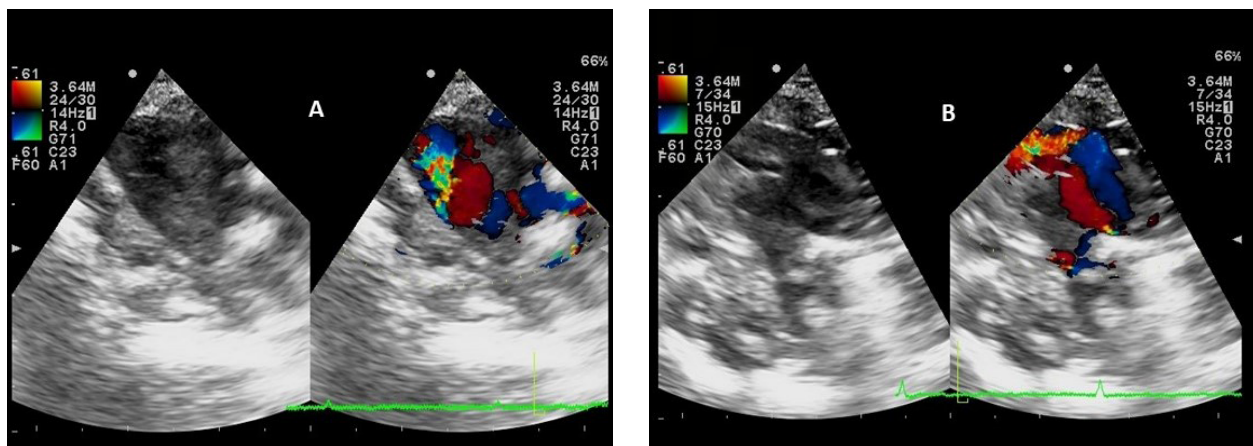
Turbulent Doppler flows recorded at the beginning and after one month of therapy
